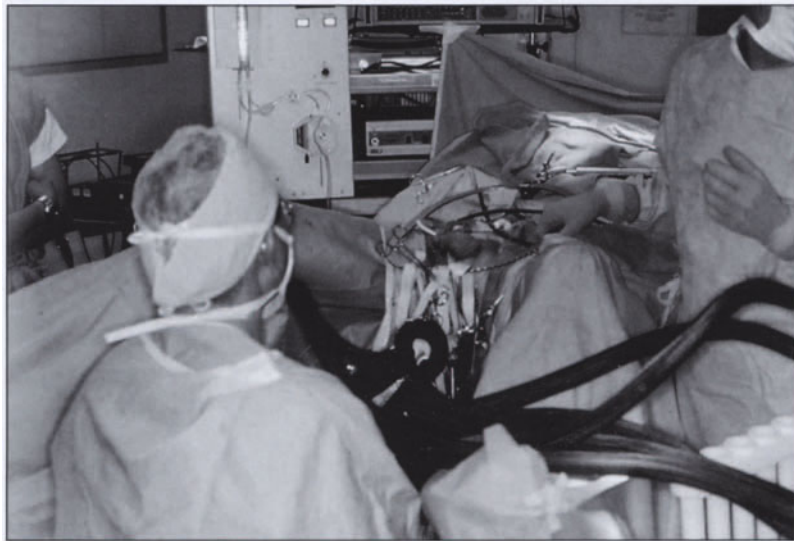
Patient positioning. After induction of regional or general anesthesia, the patient is placed in the lithotomy position. A Foley catheter is inserted, and the bladder is distended with saline to prevent the intraperitoneal contents from being close to the freezing area. Before freezing, the Foley catheter is removed and replaced with the urethral warmer, and irrigation of the catheter with warm saline is begun. The cryoprobes are placed transperineally under ultrasound guidance.
